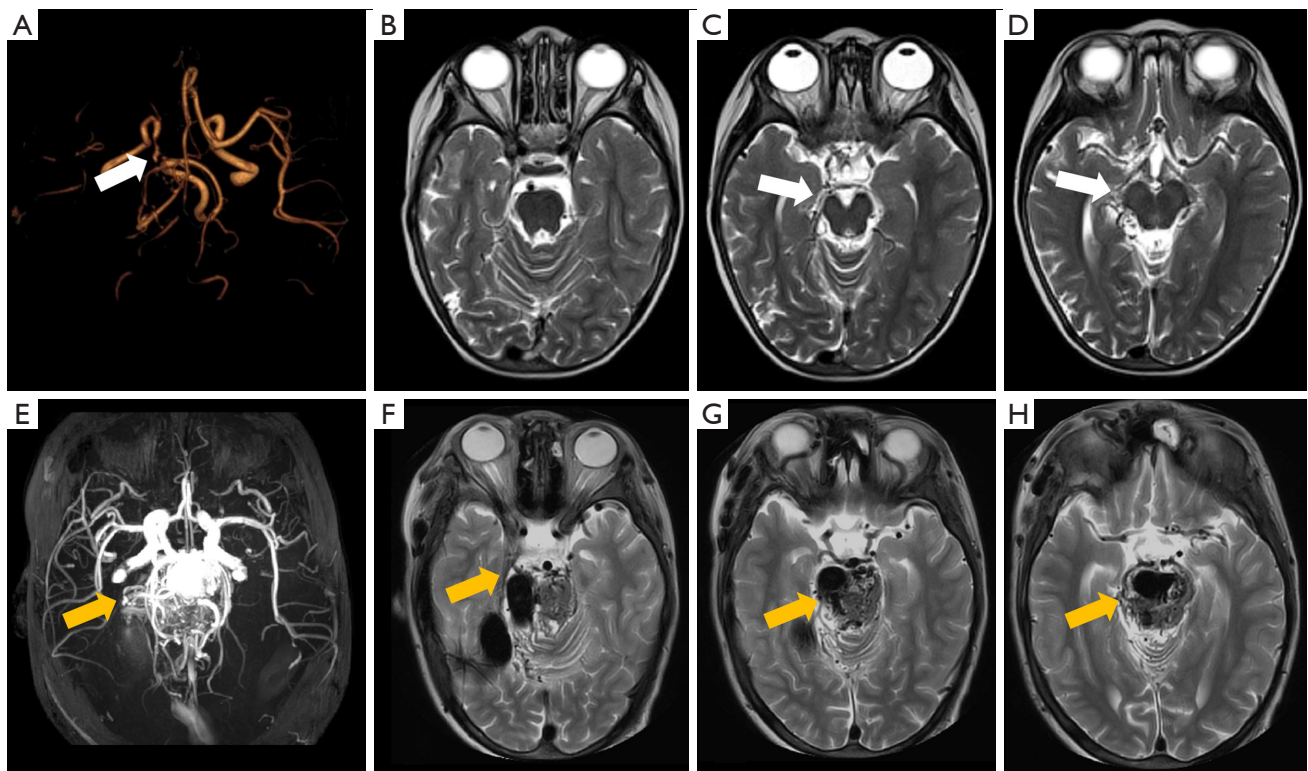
Missed and misdiagnosed cases of the Dense Convolutional Network model in site 7 (Children's Hospital of Nanjing Medical University). (A-D) A 7-year-old boy with right-sided MMA, missed by the model. MRA (A: volume rendering) revealed occlusion of the right internal carotid artery, underdeveloped right middle cerebral artery, and slender right posterior cerebral artery with collaterals (white arrow). (B-D) T2WI at the central level of the basal cistern, displayed the left middle cerebral artery M1 segment and flow voids around the right brainstem. (white arrow in C and D). (E-H) A 9-year-old boy with intracranial arteriovenous malformation, misdiagnosed as MMA. MRA (E: maximum intensity projection) showed tortuous vessels in the posterior circulation (yellow arrow). (F-H) T2WI at the central level of the basal cistern, displayed bilateral middle cerebral artery lumens and flow voids in the brainstem area (yellow arrows). MMA, moyamoya angiopathy; MRA, magnetic resonance angiography; T2WI, T2-weighted imaging.
